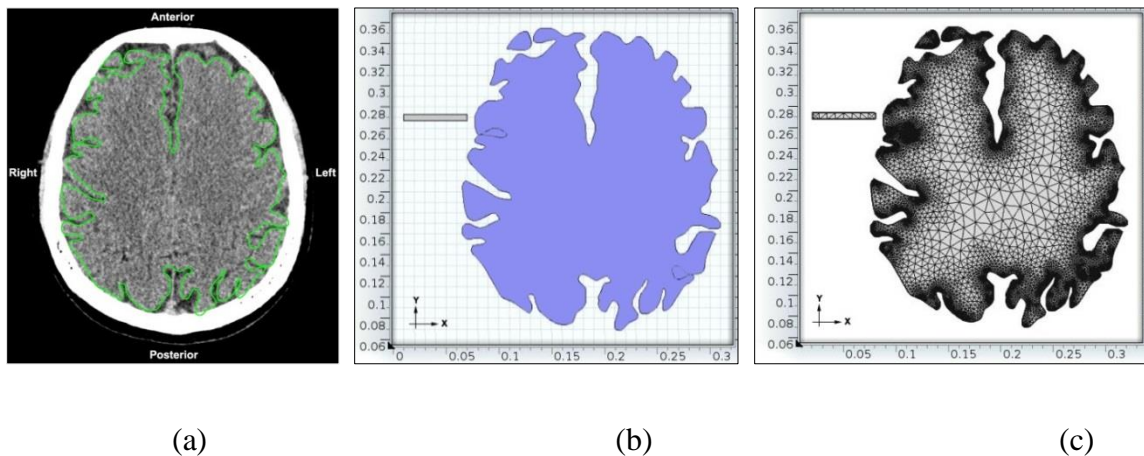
(a) Segmented CT image of the brain tissue used to construct a patient specific brain model. (b) The design of the brain model with surgical probe. (c) The meshing of the model generated by the software.
